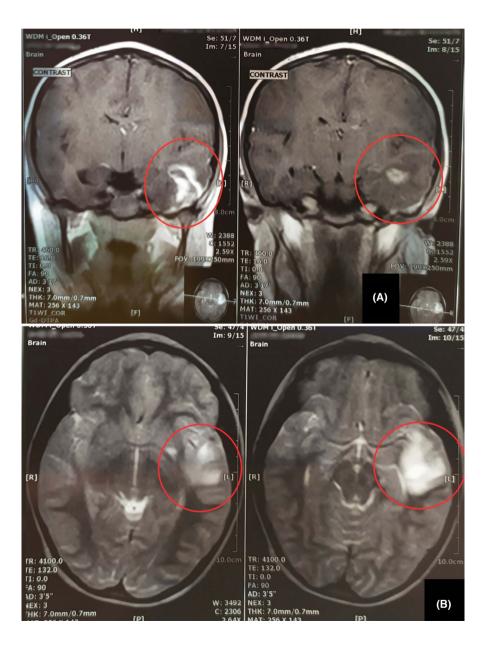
(A) Coronal T1 contrastenhanced MRI and (B) Axial T2 MRI show 24 mm mass surrounded by edema (circle)
